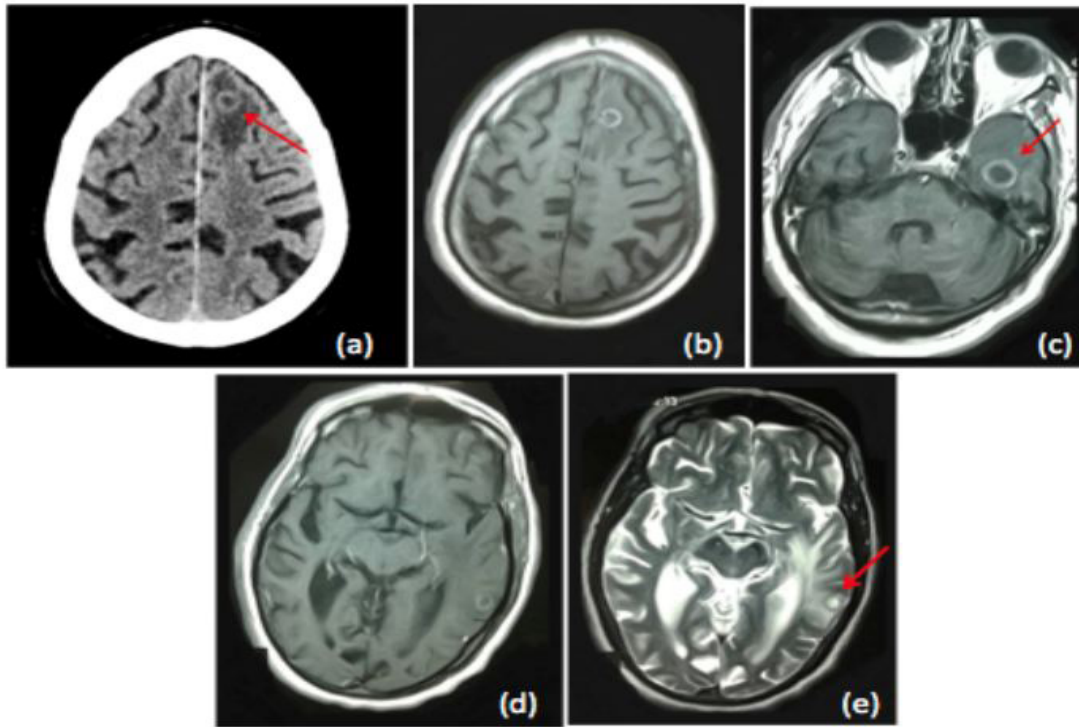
(a-e): Axial section of brain of an 80-yrs-old male with metastasized Colorectal Cancer. (a) CT brain without contrast shows a rings-like focal lesion (arrow) in the left frontal lobe with cerebral edema. (b) MRI brain (post-contrast) shows ring enhancing lesions in the left frontal lobe with cerebral edema. (c) MRI brain (post- contrast) T1 weighted image shows ring enhancing lesion in the left temporal lobe (arrow). (d) MRI brain (post-contrast) T1 weighted image shows ring enhancing lesion on the left side of brain. (e) MRI brain (post-contrast) T2 weighted image shows hyperintense lesion (arrow).
